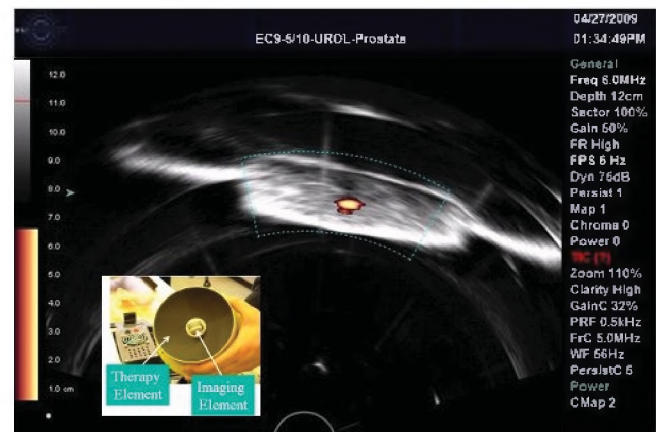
Typical B-mode and Doppler display during histotripsy exposure of pork muscle tissue showing the Doppler signal at the focal point (centre of tissue) as well as a previous HIFU lesion on the left side of the tissue. There are cm markers on the left side. The therapy beam comes from the bottom of the image. The insert shows the coaxial transducers.
